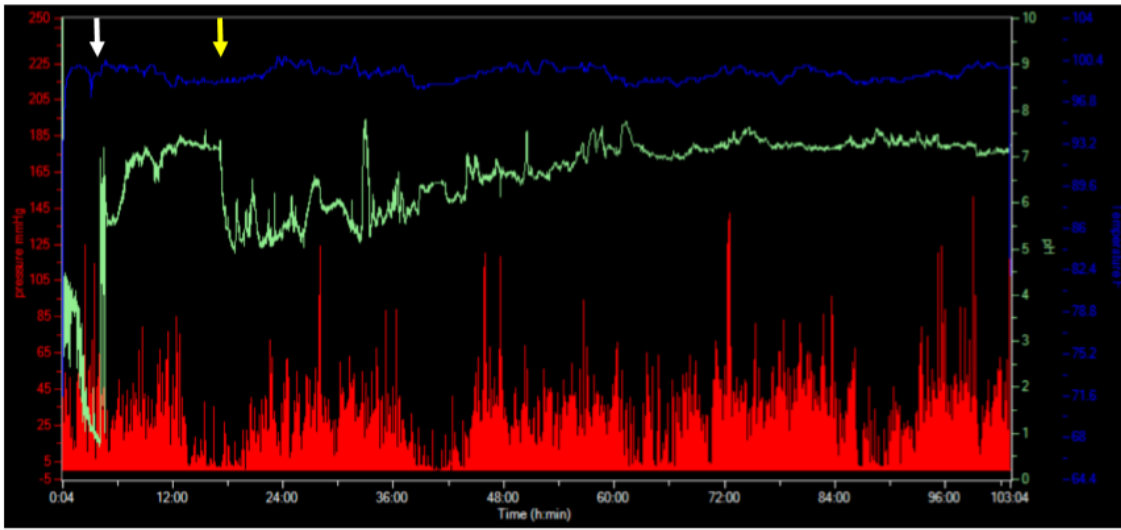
Examples of both a screening method (A: plain abdominal X-ray following previous ingestion of radio-opaque markers) and more advanced method (B: full Wireless Motility Capsule study) for the diagnostic assessment of whole-gut transit. The X-ray shows retention of all 60 ingested markers (Metcalf method:<sup>191</sup> 3 different marker sets) at 120 hr, clearly demonstrating a pathological delay in whole-gut transit ( $\geq 20\%$  of markers remaining). The Wireless Motility Capsule study (different patient) shows temperature (blue trace), pH (green trace) and pressure (red trace) changes throughout the study period. Using stereotypical alterations in the pH profile (abrupt rise [white arrow] – stomach to small bowel transition, and sharp drop [yellow arrow] – small to large bowel transition), regional GI transit can be determined. This recording shows normal gastric emptying (3 hr 55 min; upper limit of normal: 5 hr<sup>188</sup>), but a pathological delay in transit through both the small bowel (13 hr 3 min; upper limit of normal: 8 hr<sup>188</sup>) and colon (85 hr 45 min; upper limit of normal: 50 hr 30 min<sup>188</sup>). Whole-gut transit time (from ingestion, left border of recording to expulsion, left border of recording) is also delayed (102 hr 44 min; upper limit of normal: 68 hr 45 min<sup>188</sup>).
